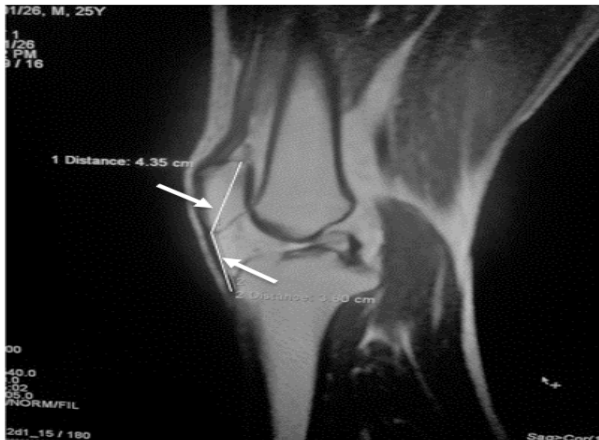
T1 W image of MRI in mid sagittal plane showing measurement of patellar tendon length TL (distance 2) and patellar length PL (distance 1) for calculation of Insall-Salvati ratio (TL/PL).
